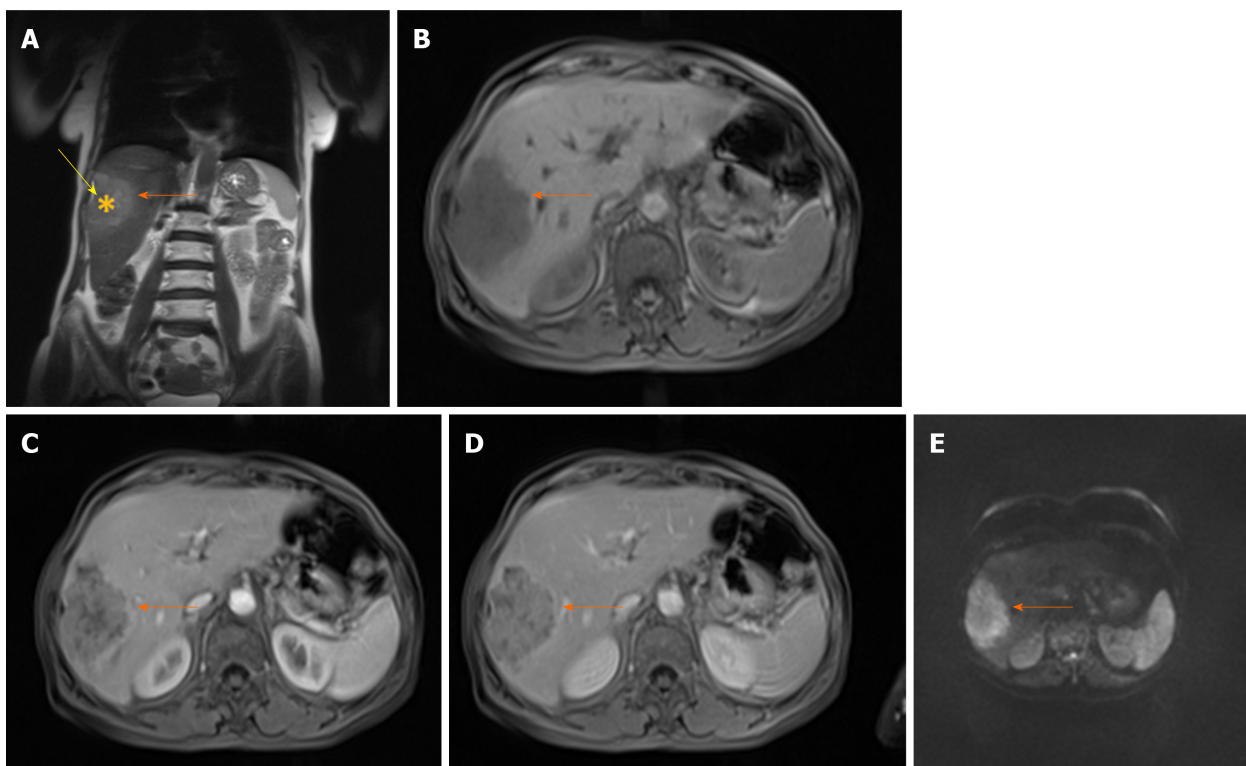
Scirrhous hepatocellular carcinoma in 68-year old woman with chronic hepatitis C infection. A: Coronal T2-weighted image shows moderately hyperintense subcapsular located lesion in segments VI and V (orange arrow); B-D: The tumor (orange arrows) is hypointense on axial T1-weighted FS image (B), hypervascular on arterial phase (C) with only small regions of washout in portal venous phase (D); E: On diffusion-weighted image the lesion is hyperintense. Note also capsular retraction on A (yellow arrow).
